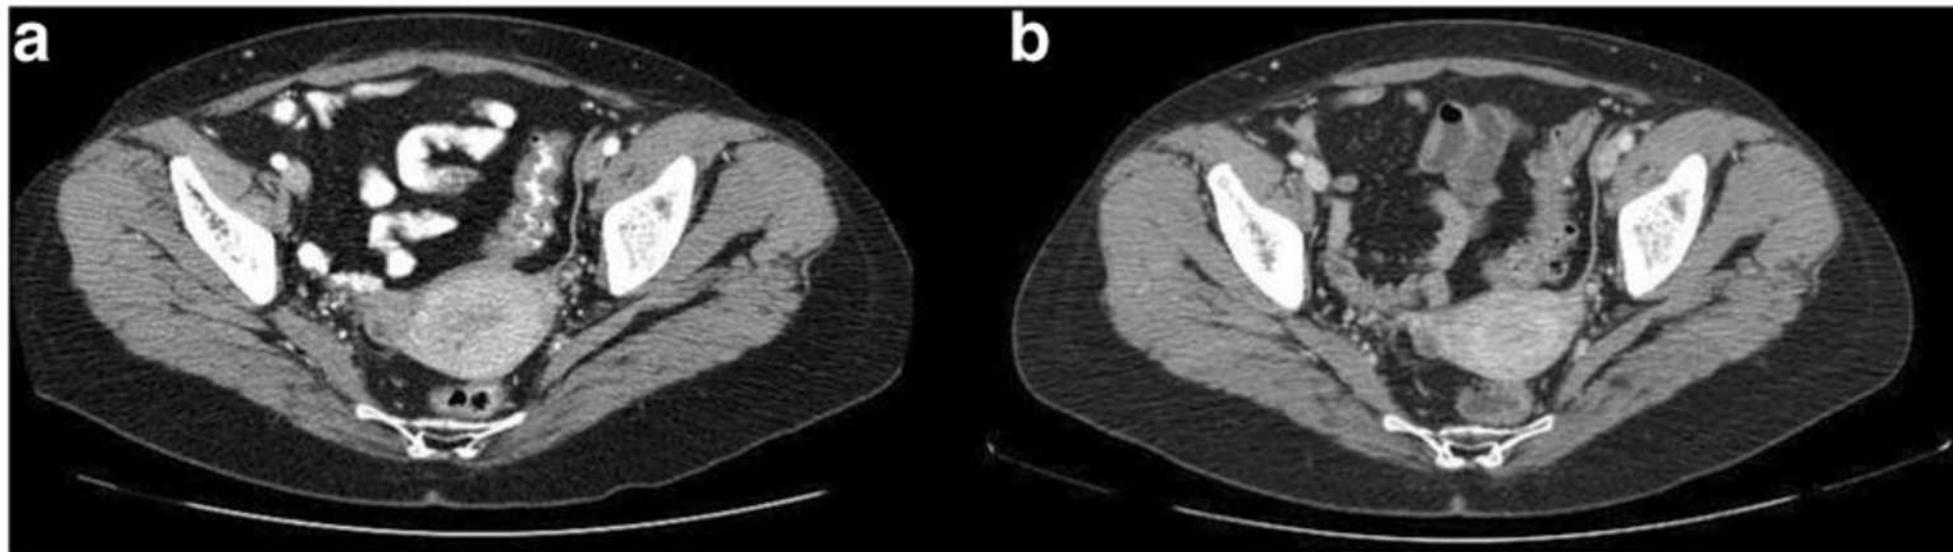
a Control CT image with positive OCM in a female patient. The uterus can be easily visualised and discriminated from the adjacent bowel loops filled with high-attenuating positive OCM. However, mural detail cannot be appreciated. b Follow-up CT image with water in the same
